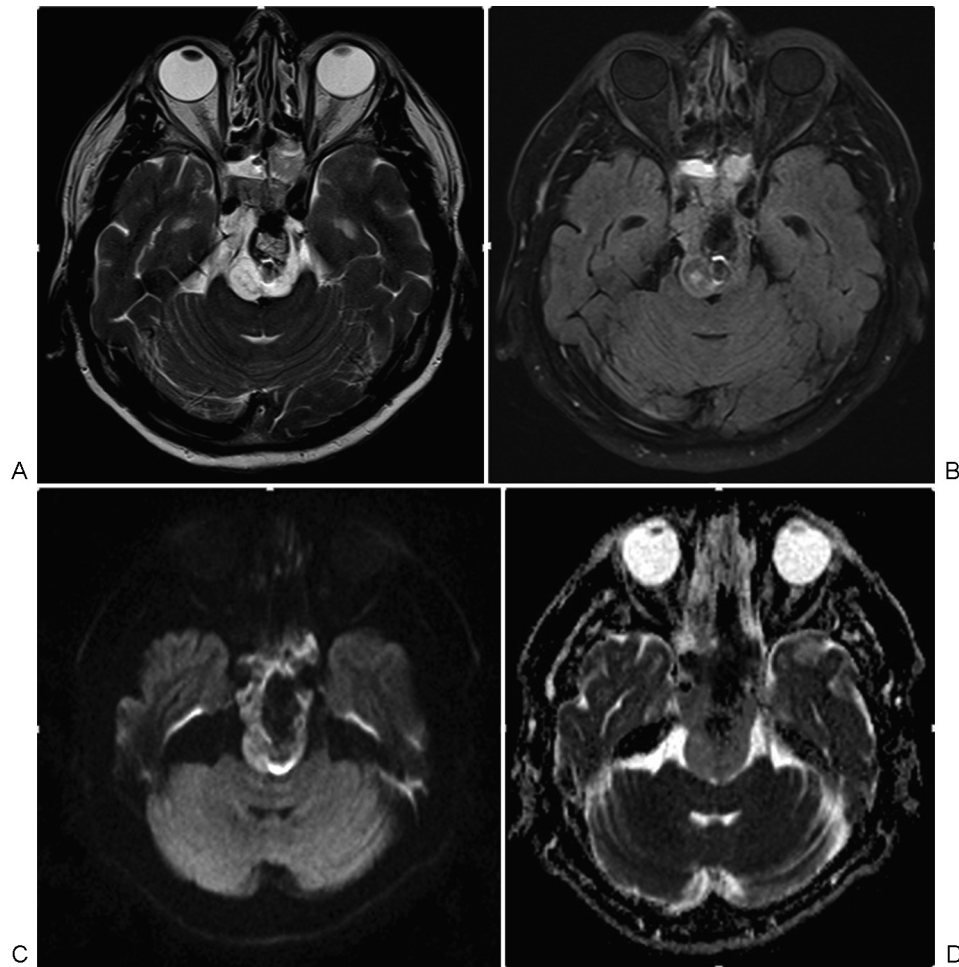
Postoperative magnetic resonance images of the same patient in Fig. 3. The mass is partially resected and a residual tumor with high signal intensity in axial T2-weighted image (A) and intermediate signal intensity in axial fluid-attenuated inversion recovery image (B) is seen with evidence of hemorrhage centrally. Diffusion-weighted trace image (C) and corresponding apparent diffusion coefficient map (D) reveal a better demarcation of the residual tumor. Note slight artifacts in the resection cavity caused by surgical materials and hemorrhage.
